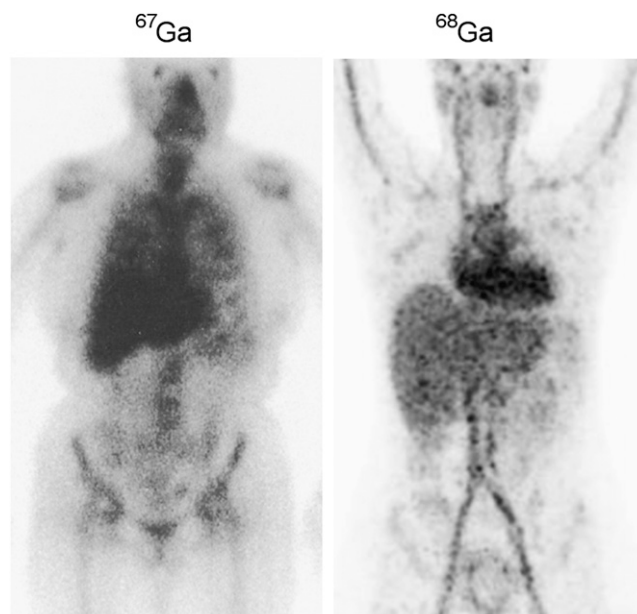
Physiologic biodistribution of ⁶⁷Ga-citrate whole-body scintigraphy and ⁶⁸Ga-citrate PET/CT.
